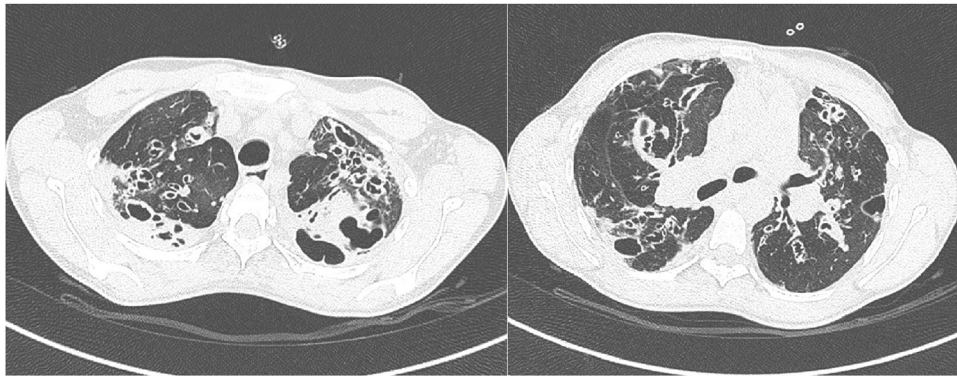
Recipient CT-scan before transplantation.
